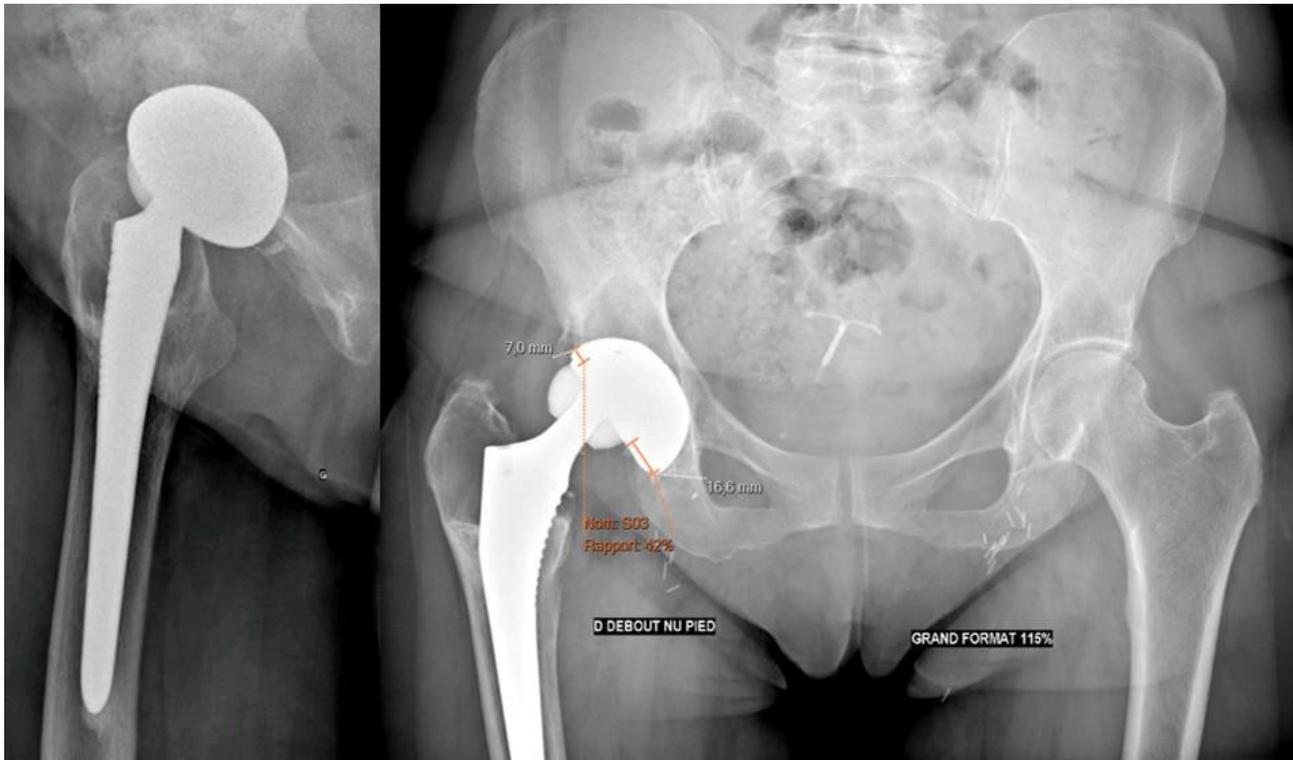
Anteroposterior pelvic and lateral right hip radiographs, 2024, showing 42% eccentricity of the prosthetic femoral head
